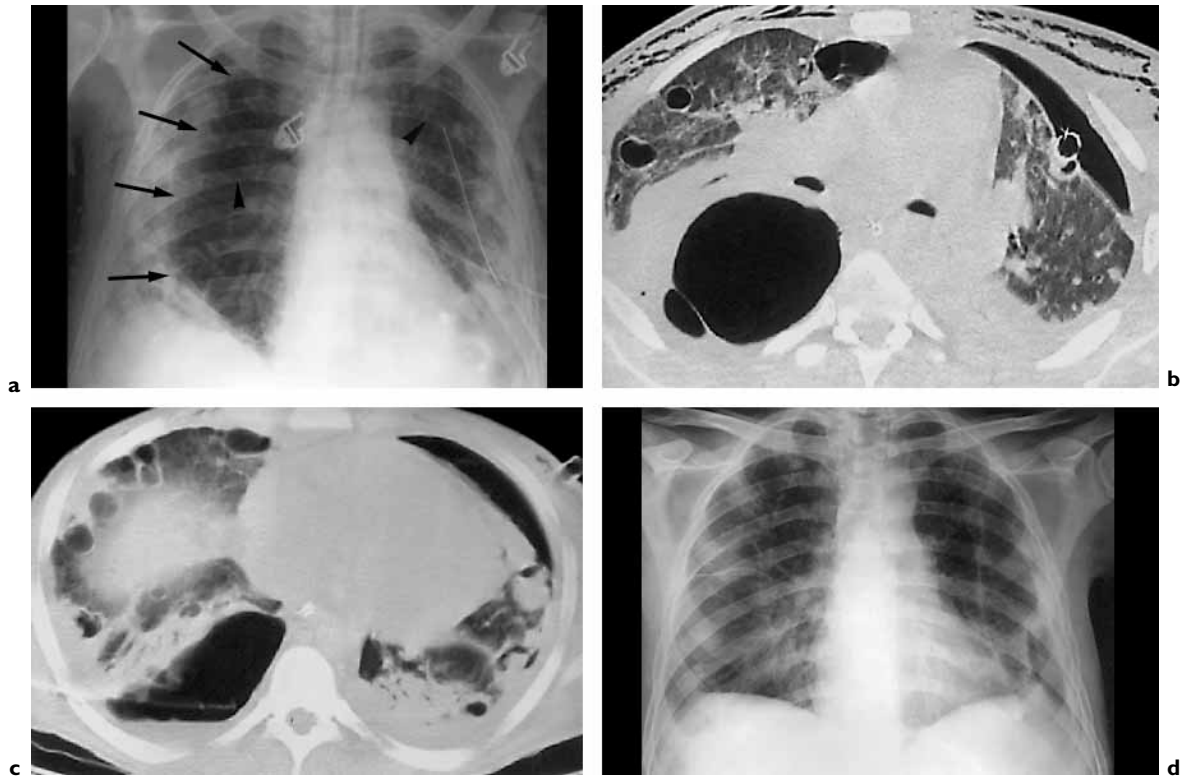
Percutaneous drainage of a pneumatocele. a A 24-year-old intravenous drug addict presented with pulmonary staphylococcus infection following endocarditis. Recurrent left-sided pneumothorax was treated by multiple thoracostomy tubes. Severe respiratory failure developed along with a rapidly growing lung lucency (arrows) compressing the normal parenchyma on the right side. Note the multiple cavitated nodules (arrowheads) on both sides. b CT confirmed a large right posterior pneumatocele and a small left pneumothorax with well-positioned chest tubes. c A 9F pigtail catheter was inserted under CT guidance in the pneumatocele, which dramatically improved the patient's symptoms. d After 3 weeks of negative waterseal aspiration, a chest X-ray confirmed complete regression of the pneumatocele.
